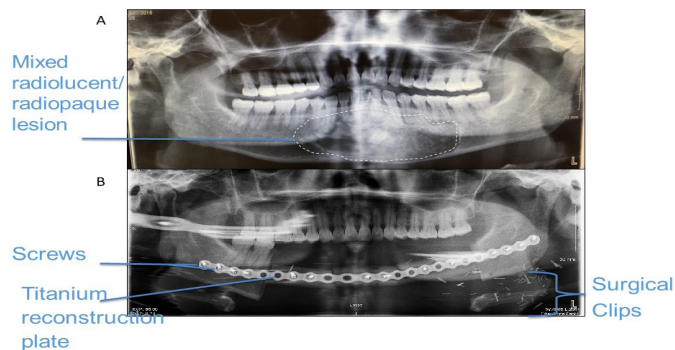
Pre and post operative plain film orthopantograms showing ossifying fibroma completely resected and reconstruction.
